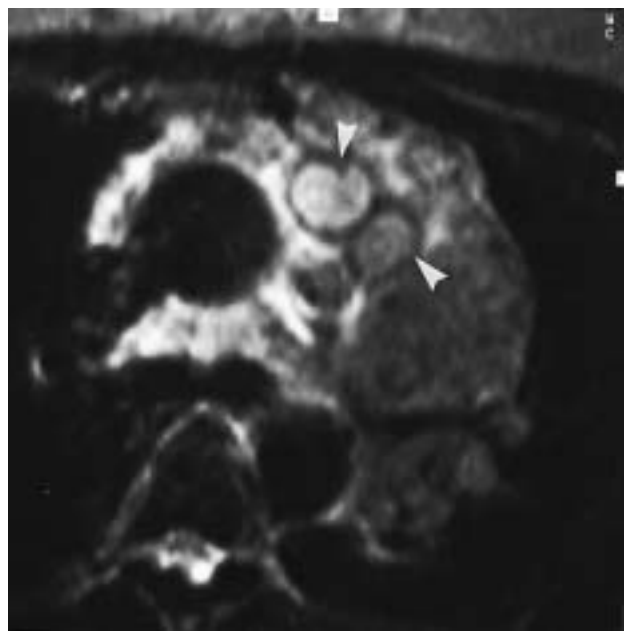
Hodgkin's disease, nodular-sclerosing type. Transverse T2-weighted image shows inhomogeneous signal intensity with ring-shaped low-signal fibrosis (arrowheads); typical appearance of nodular-sclerosing Hodgkin's lymphoma.
